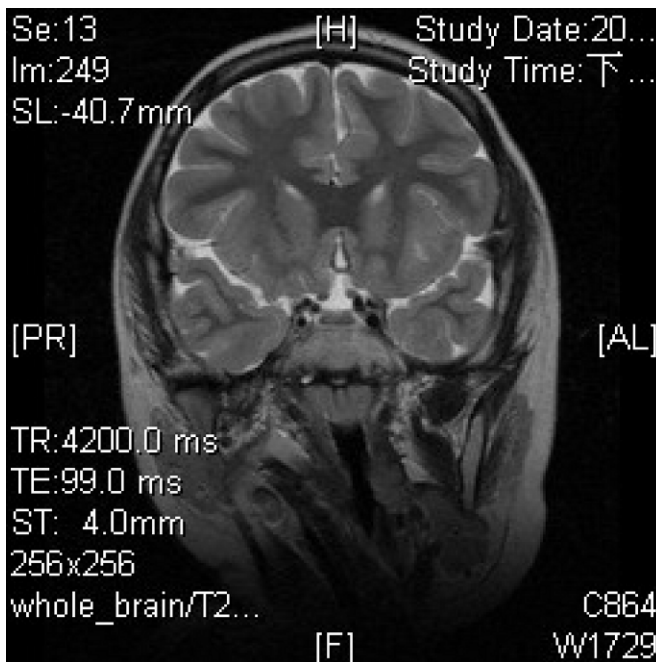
Coronal magnetic resonance T2-weighted imaging showed abnormal high signal around the right carotid siphon at the right cavernous sinus region, which support the diagnosis of intimal tear of the internal carotid artery.
